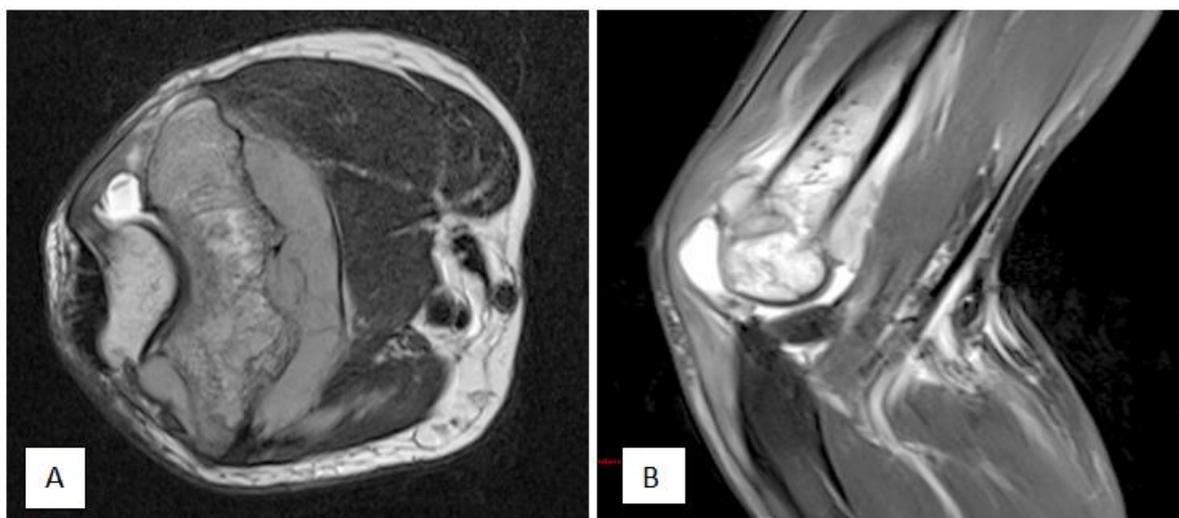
MRI that highlighted a tumor lesion affecting the lower end of the left humerus, infiltrating the synovium; A: Axial image in T1 sequence. B: Sagittal image in STIR sequence
